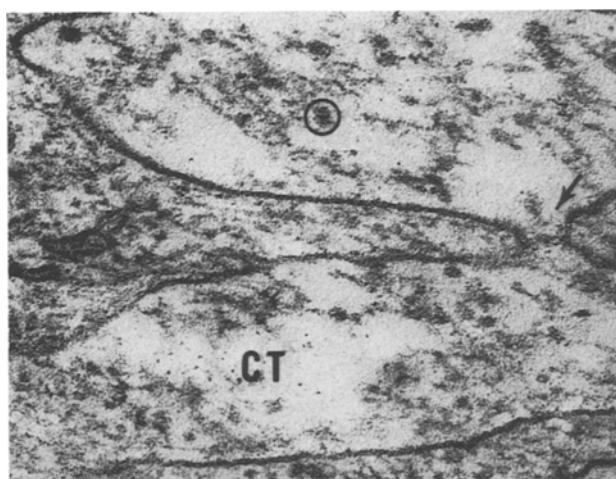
Venous limb of a capillary in an intestinal villus. There are numerous particles (circles) which resemble lipoproteins as seen in mammals. They are present in the connective tissue (CT) and lumen. One is very close to a fenestra (arrow). $\times 100,000$.
